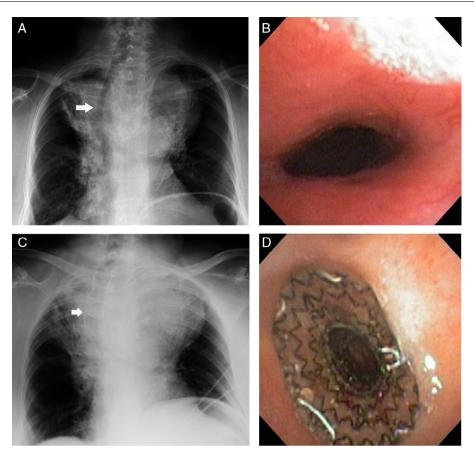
(A) Chest X-ray showing a large mediastinal mass with marked deviation of the trachea to the right with tracheal compression, (B) bronchoscopic view of the trachea showing the narrowing, (C) chest X-ray after the stent placement showing the stent in the trachea, and (D) bronchoscopic view of the tracheal stent.
